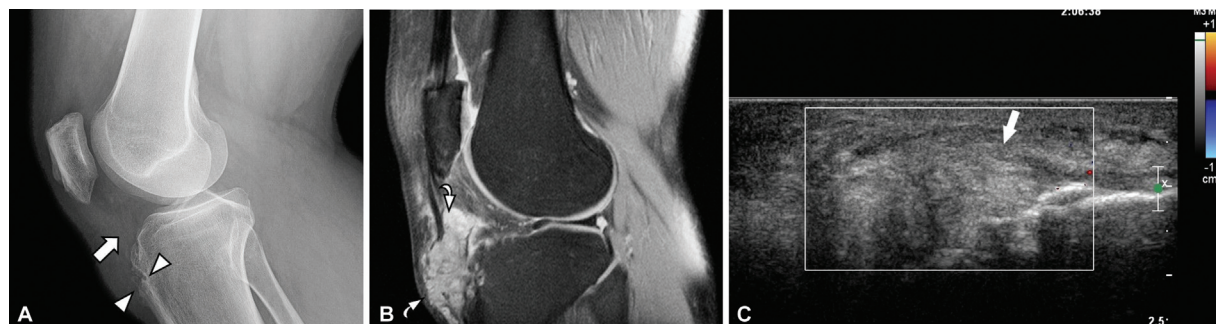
A 52-year-old man with palpable anterior knee mass and gout. (A) Lateral knee radiograph shows increased soft tissue density (*arrow*) in Hoffa's fat and bony erosions (*arrowheads*) at the tibial tuberosity. (B) Sagittal short-tau inversion recovery (STIR) magnetic resonance (MR) image shows an irregular, hyperintense lobulated mass (*curved arrow*), consistent with gouty tophi. (C) Ultrasound image shows a hyperechoic mass (*arrow*) without vascularity.
